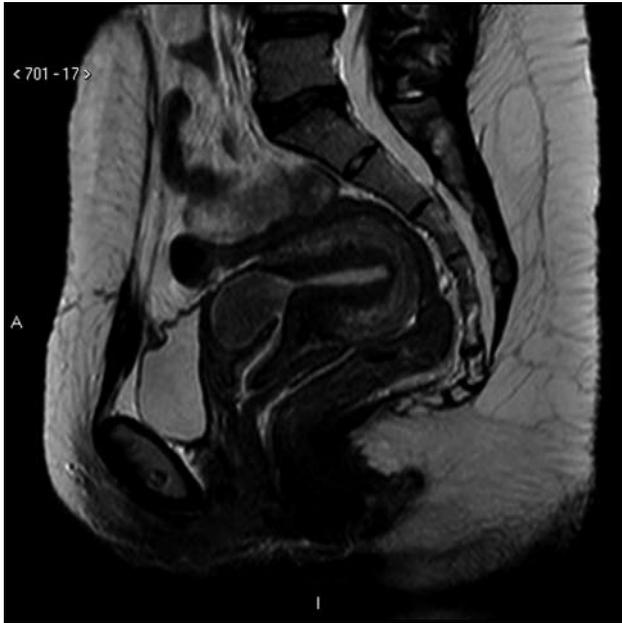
Sagittal T2-weighted image clearly showing a retroflexed uterus. In the anterior wall of the uterine isthmus, at the site of a previous cesarean delivery scar, there is a pouch (35 mm deep). In this site the uterine wall is represented only by a very subtle layer of myometrium with a thin layer of endometrium lining the inner wall of the pouch. The sacular pouch appeared in continuity with the endometrial line by a neck of 15 mm.
